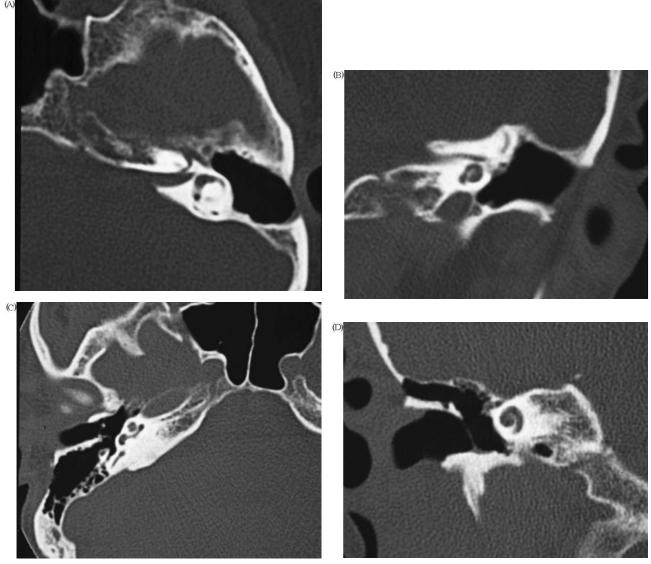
Postoperative middle ear. (A and B) Radical mastoidectomy for COM. Normal CT findings encompass the absence of the ossicular chain, mastoid cells, lateral middle ear wall and eardrum. Normal air content within the postsurgical cavity is appreciated. (C and D). Closed tympanoplasty for COM. A defect on the outer aspect of the mastoid suggests partial mastoidectomy. The ossicular chain has not yet been reconstructed. Part of the residual malleus is detected on the axial plane (arrow). The tympanic membrane reaches the scutum showing a quite normal appearance. Normal air content within the middle ear cleft.
